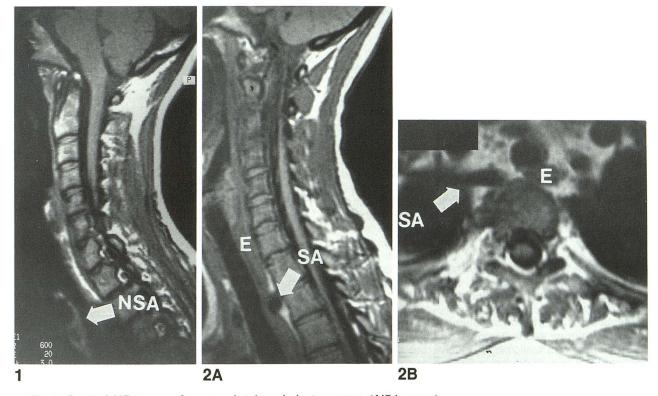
Sagittal MR image of a normal right subclavian artery (*NSA arrow*).
